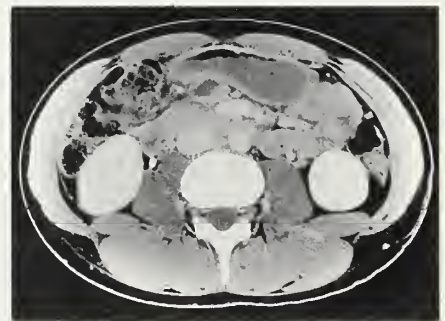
Follow-up CT scan of the abdomen done six weeks post-injury showing almost complete resolution of the pancreatic pseudocyst.
